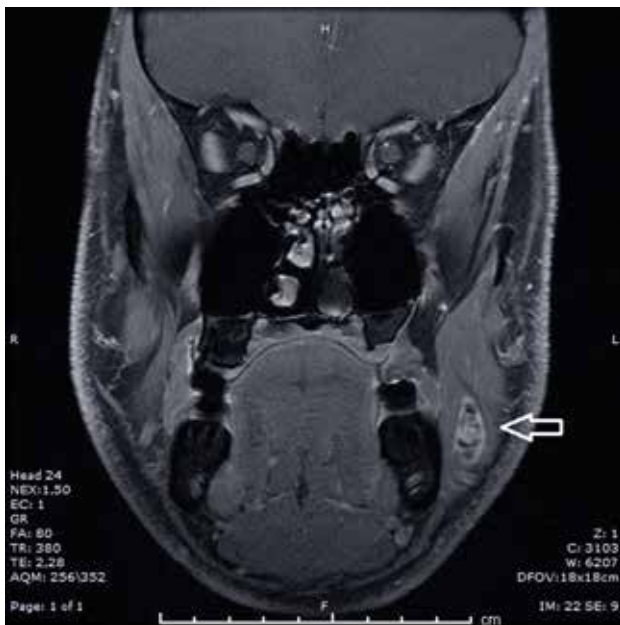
Coronal contrast-enhanced magnetic resonance imaging showing a lesion approximately 20×12×8 mm in anteroinferior of masseter muscle.
